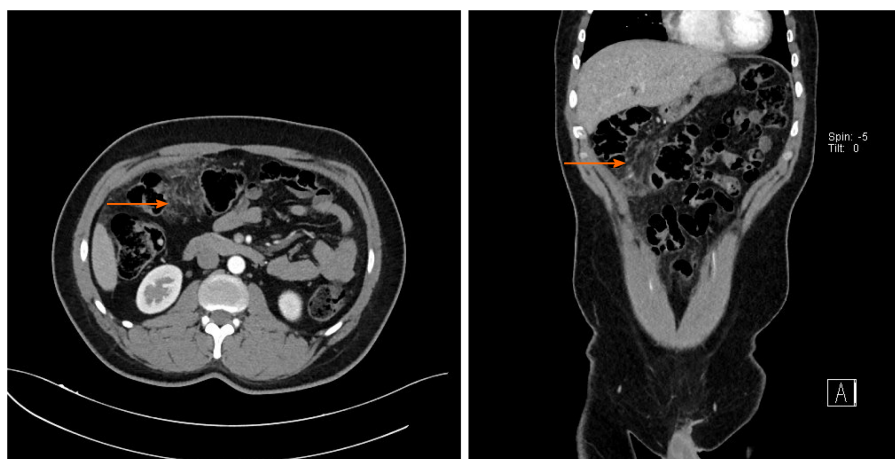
Computed tomography image of a patient with omental necrosis (arrow) detected in the postoperative period.
